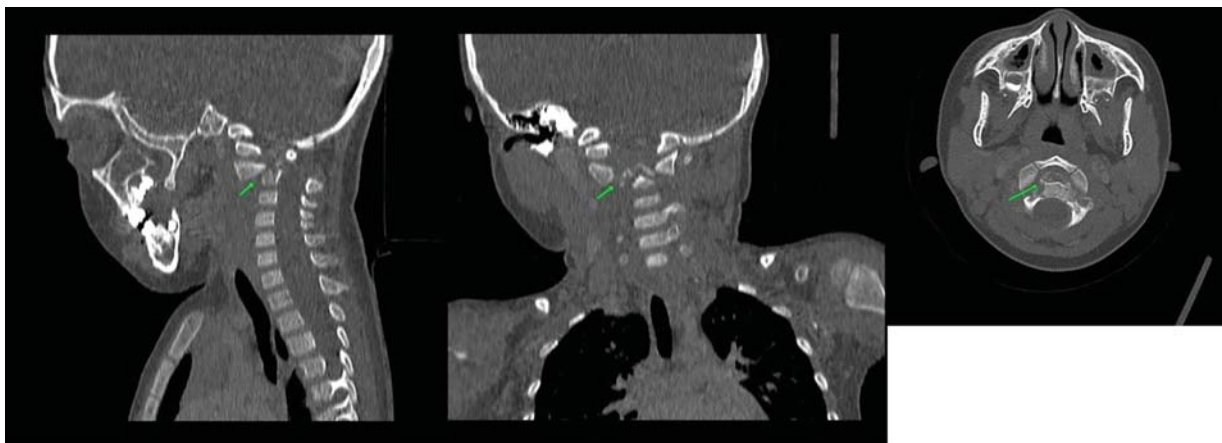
Contrast-enhanced computed tomography neck; arrow showed subluxation of C1/C2 (sagittal, coronal, and axial view).
